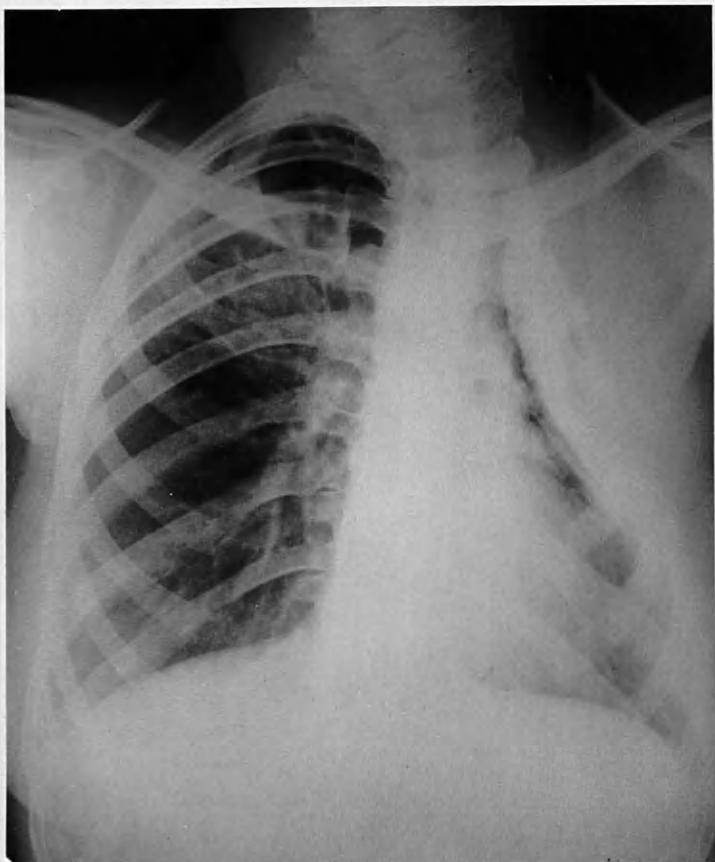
Radiograph taken on 31.12.52. There has been a bronchogenic spread of the disease, as seen by the diffuse shadowing in the right upper and mid-zones. The cavity is clearly visible in the first intercostal space.
